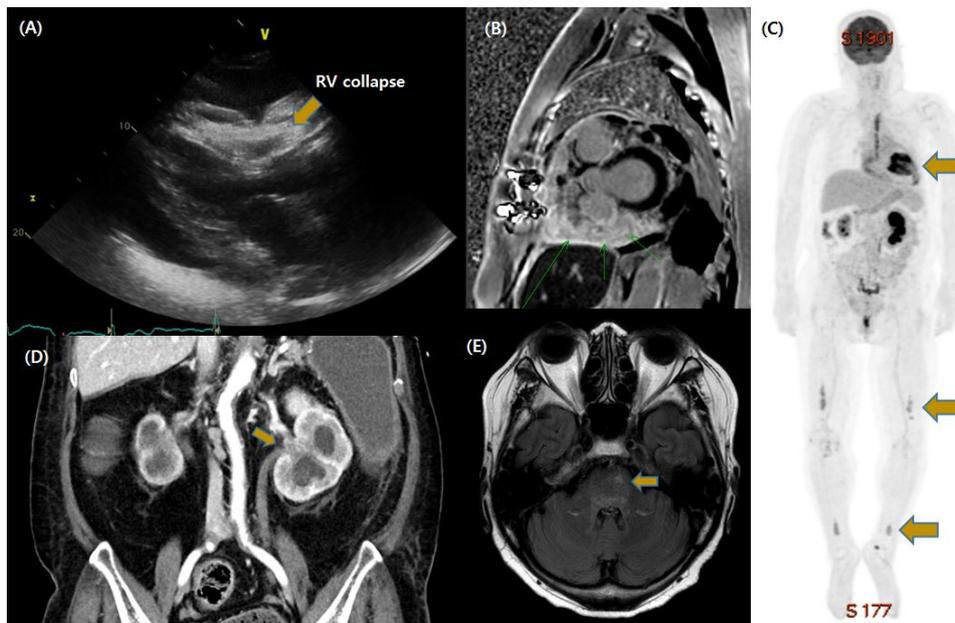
A) TTE Parasternal long axis view, large amount of PE with hemodynamic compromise, B) Cardiac MRI, diffuse pericardial enhancement with thickening, C) PET-CT, FDG uptake along pericardium and both distal femoral and distal tibia, D) APCT, soft tissue infiltration at bilateral renal pelvis and left proximal ureter, E) Brain MRI, subtle T2 high signal intensity in pons
